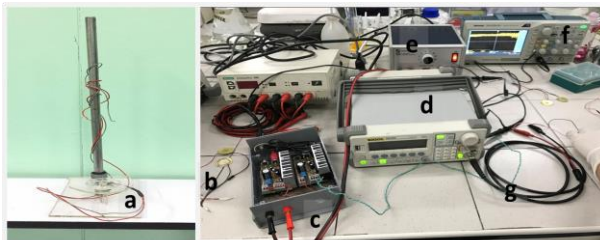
Low energy focused ultrasound setup. a. Three pin line b. piezoelectric transducer c. amplifier d. arbitrary waveform generator e. power supply f. digital oscilloscope g. cables.
